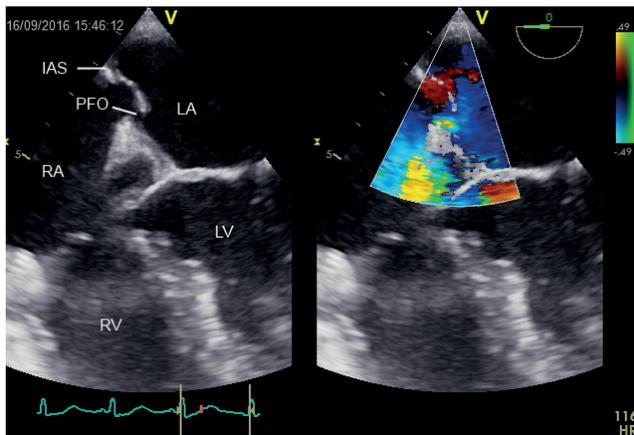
Still of a transesophageal echocardiography, demonstrating a patent foramen ovale (PFO) with intermittent flow (right to left shunt) RA = right atrium; LA = left atrium; RV = right ventricle; LV= left ventricle; IAS = interatrial septum.
